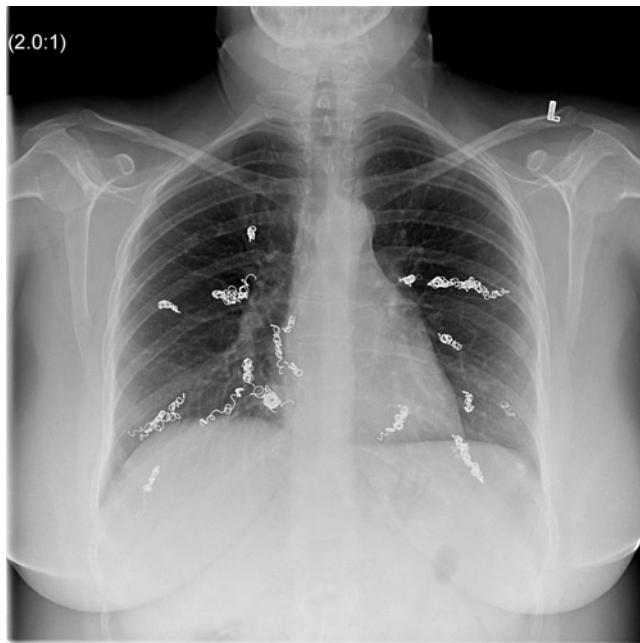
Chest X-ray of a patient with hereditary hemorrhagic telangiectasia (HHT) who has been treated for recurrent episodes of hemoptysis. Multiple bilateral radiographic coils can be seen which have been placed in pulmonary AVMs.
